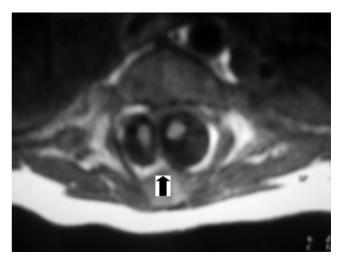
Postnatal T1-weighted magnetic resonance image showing diastematomyelia: the arrow shows the septum dividing the spinal canal from the anterior wall to the posterior wall.
